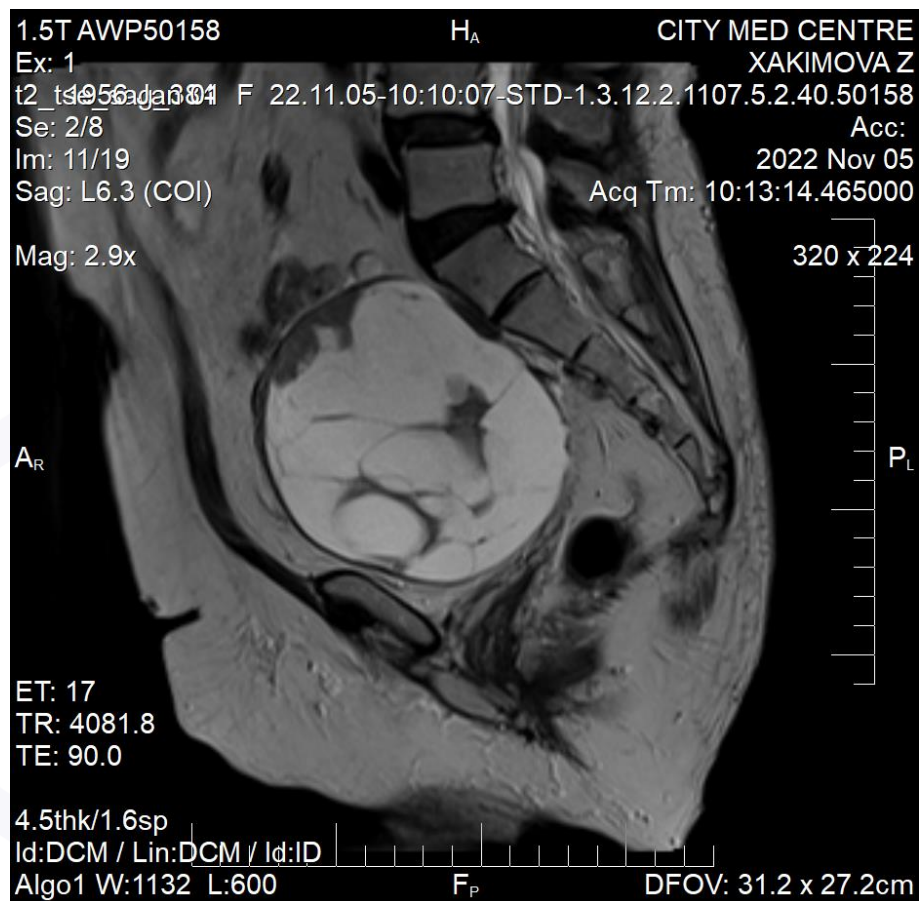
MRI examination of the small pelvis. MRI - signs of uterine fibroids.
